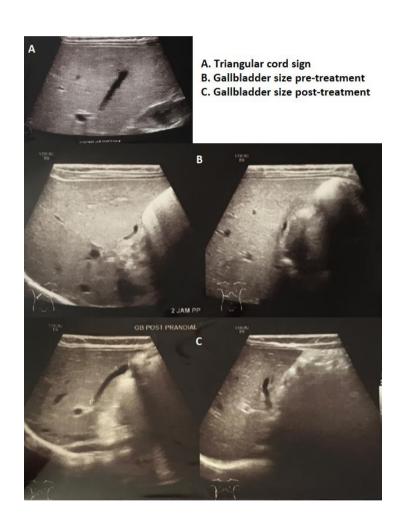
Two-phase abdominal ultrasound follow up after therapy.
